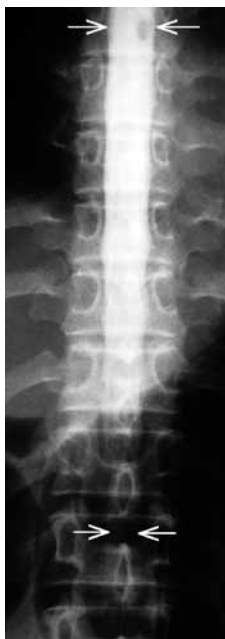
AP radiograph following 6 mL injection, with a mass of subarachnoid contrast extending from T7 to L2 (arrowed)
